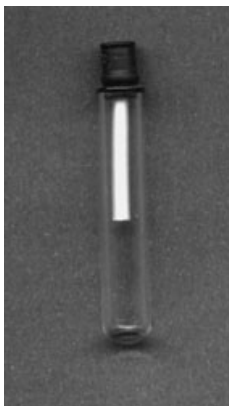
Photograph of the experimental set-up imitating a periapical environment and showing a 17.0-mm-long glass tube positioned inside the glass vial, which contained 2.5 ml distilled water at pH 7.4. The glass tube was filled with the test calcium hydroxide material, which released hydroxyl ions through a 1.0 mm opening into the medium. The subsequent change in pH was then measured over four time periods.
